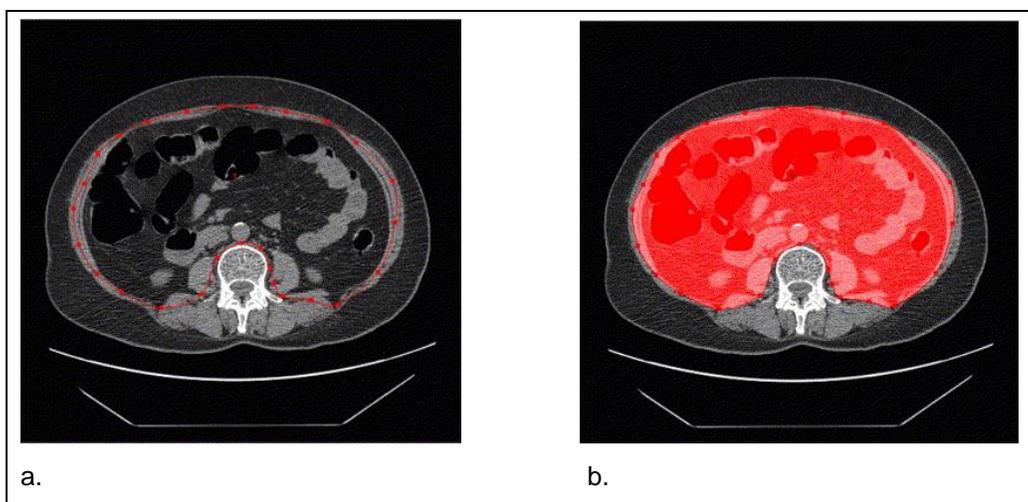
CT scan images showing a slice taken through the umbilicus. (a) The tracing of the body wall using the spline tool. Multiple points can be made using the spline tool to accurately outline the visceral fat. (b) The highlighted region of interest to be analyzed.
